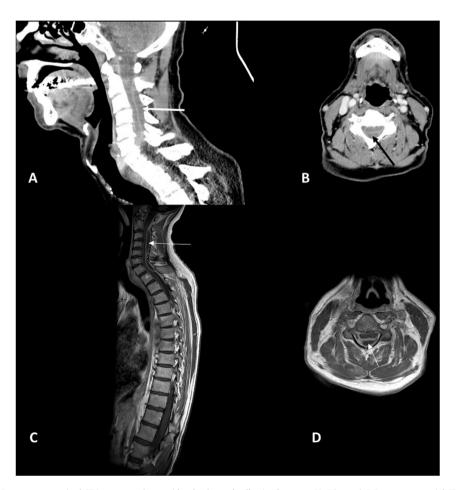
Pre-operative images. A Post contrast sagittal CT image reveals an epidural enhanced collection between C2-6 (arrow). B Post contrast axial CT image at C4 level showing the epidural abscess (arrow). C Post GAD T1W sagittal image demonstrating an enhanced epidural abscess extending from C2 to T1 (arrow). D Post GAD axial T1W image at C4 revealing the enhanced epidural abscess with spinal cord compression (arrow).
